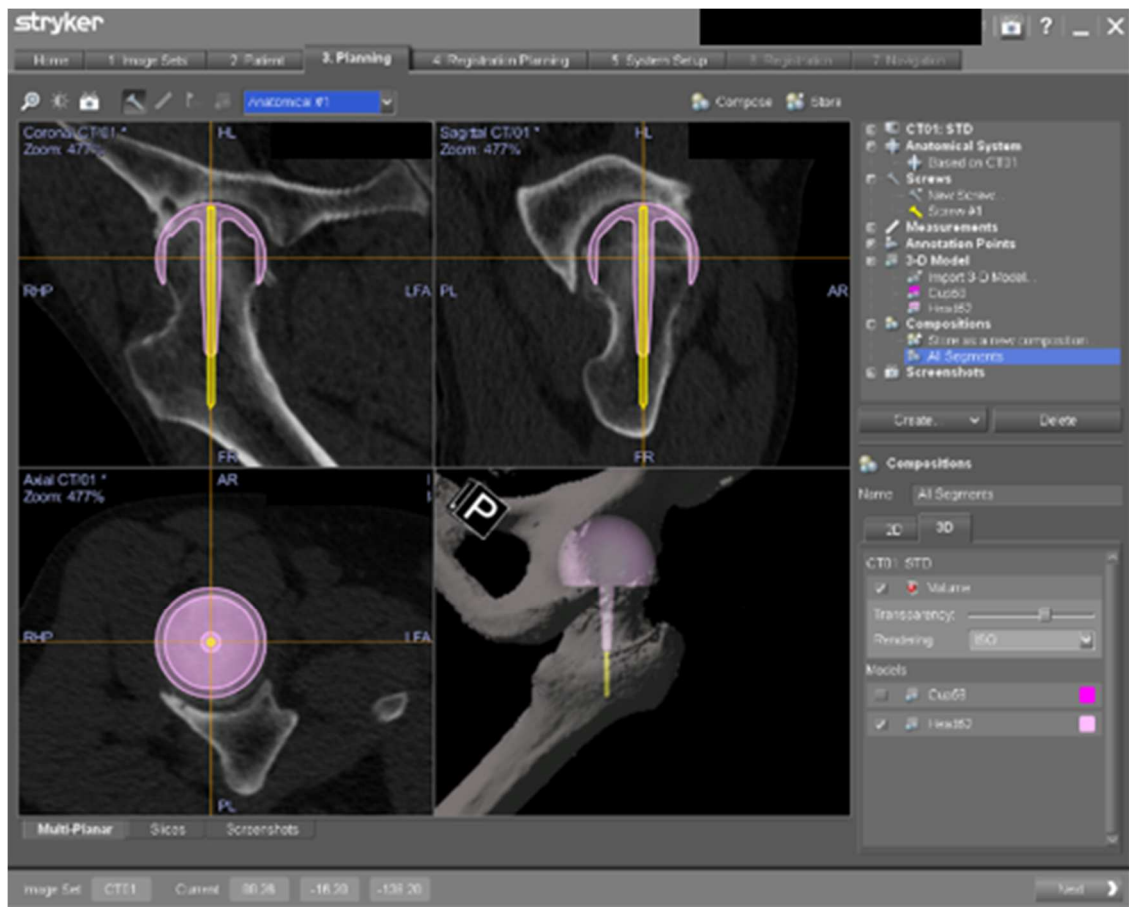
Preoperative planning for femoral component placement was performed using the planning module of the computed tomography (CT)-based navigation system
